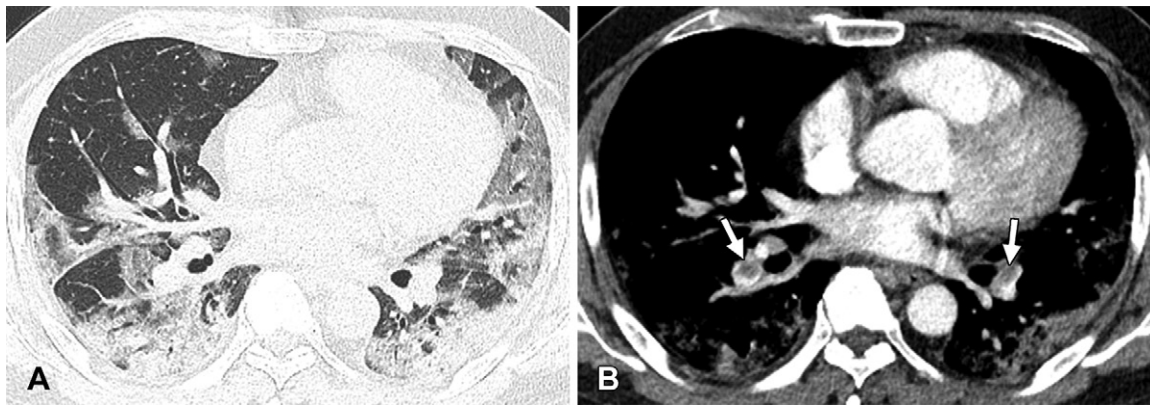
Pulmonary embolisms in a 47-year-old unvaccinated diabetic man with COVID-19 seen at Omicron variant–dominant period. (A) Transverse nonenhanced CT scan (lung window) obtained at the level of basal trunks shows bilateral mixed areas of ground-glass opacity and consolidation distributed along bronchovascular bundles or subpleural lungs. (B) Contrast-enhanced CT scan (mediastinal window) obtained at a similar level to A demonstrates nonocclusive clots in bilateral basal trunk arteries (arrows) along with lung parenchymal lesions.
